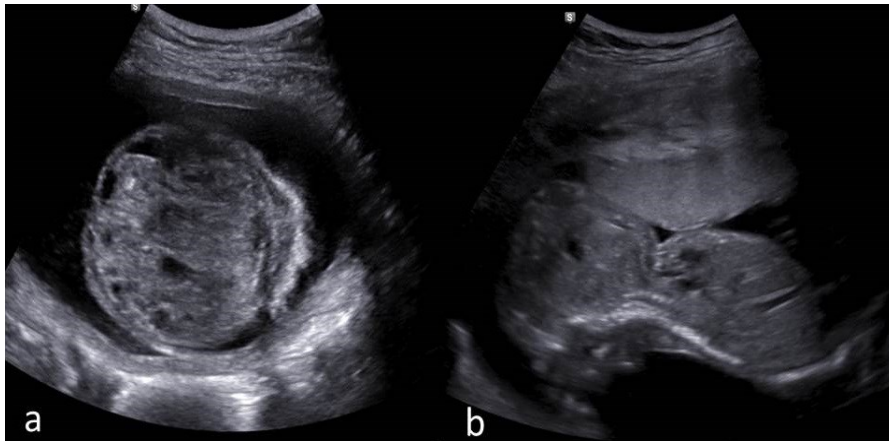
Ultrasound images showing solid-cystic mass extending from anterior neck on axial (a) and sagittal (b) planes.
